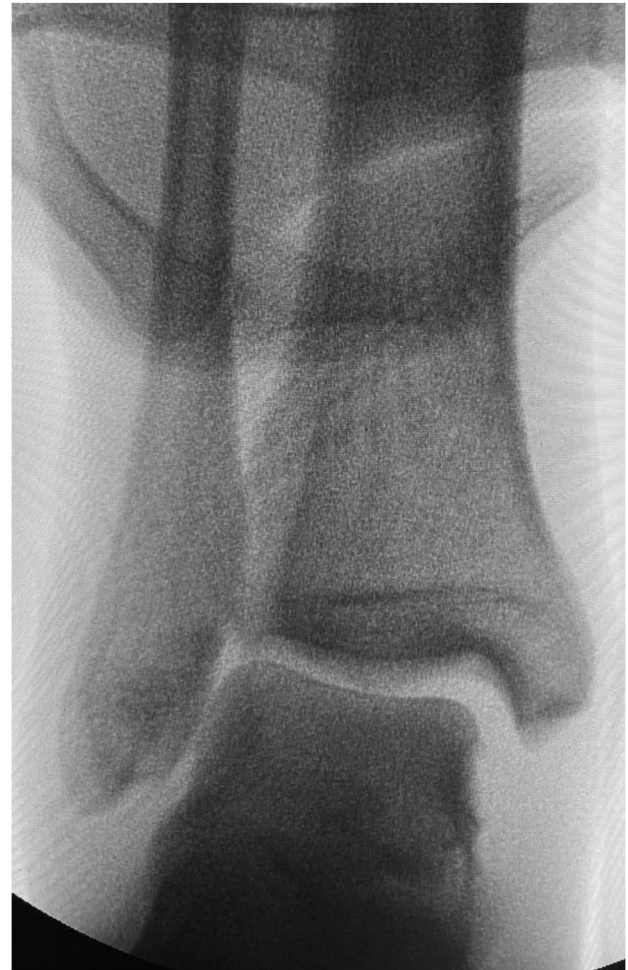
Stress radiograph of the right ankle demonstrating increased medial clear space, increased tibiofibular clear space, and decreased tibiofibular overlap.
